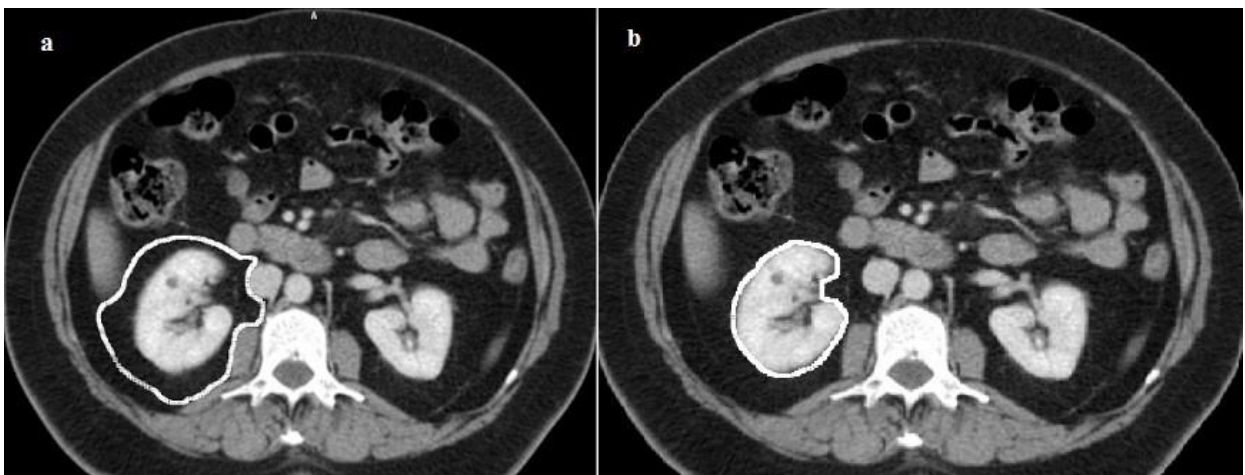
By measuring circumference of perirenal adipose tissue at the side of fat tissue contours (a) and extracting the value of circumference of renal limits (b), on axial CT images at the level of right renal hilum, we get perirenal adipose tissue area.
